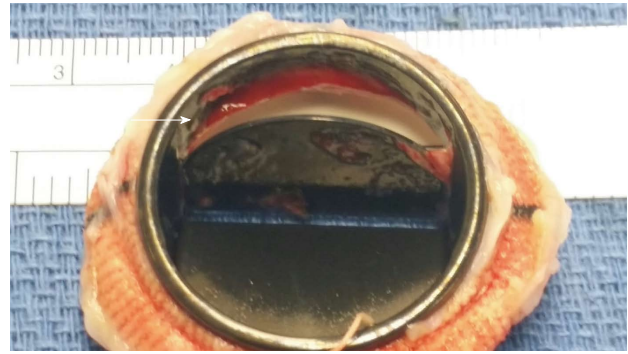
Gross sample of explanted mechanical mitral valve revealing the transesophageal echocardiography finding residual organized thrombus, apparent on the mitral valve disc (arrow).
